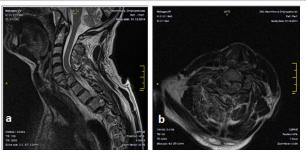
Magnetic resonance imaging of Case 1. A dislocation fracture of C6–C7 can be observed, along with myelopathy at the level of C6–C7. (a) Sagittal view (b) Axial view
